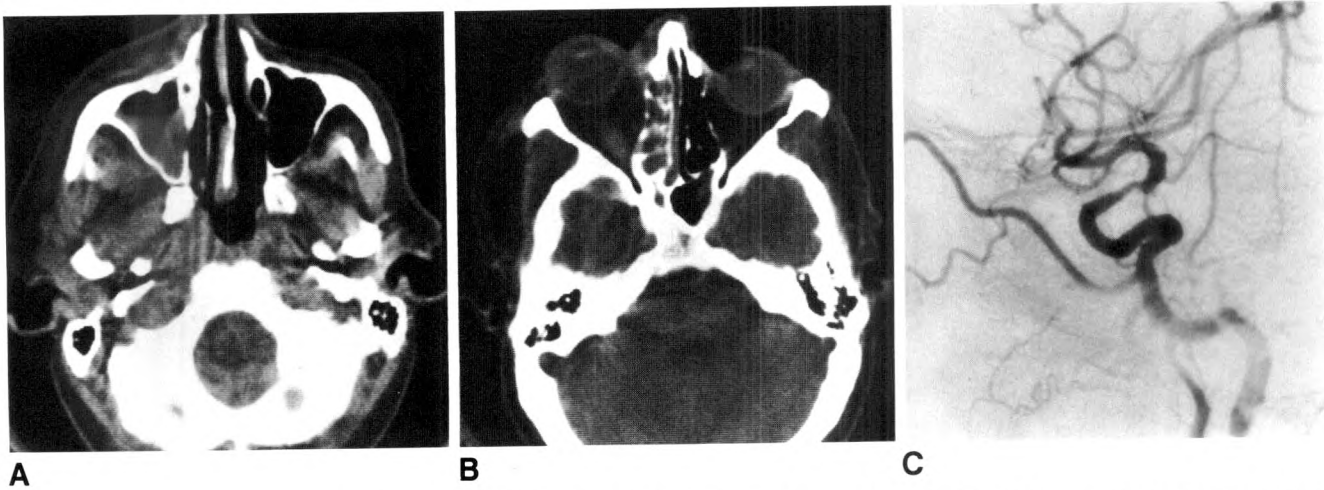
Case 3: 53-year-old man with 3-day history of facial pain and right proptosis progressing to lethargy and left hemiparesis. A, CT scan, maxillary sinus level. B, CT scan of orbits. C, Lateral view, right common carotid angiogram.
